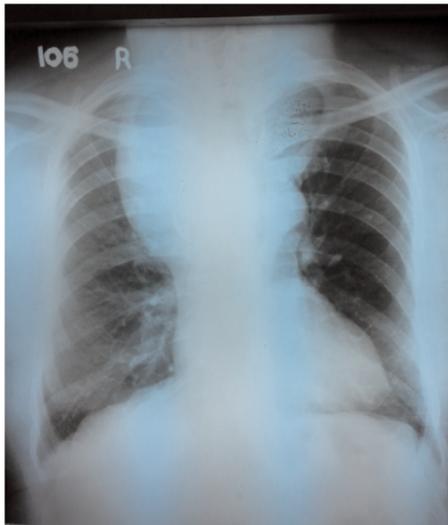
Chest radiograph revealing the mediastinal mass
